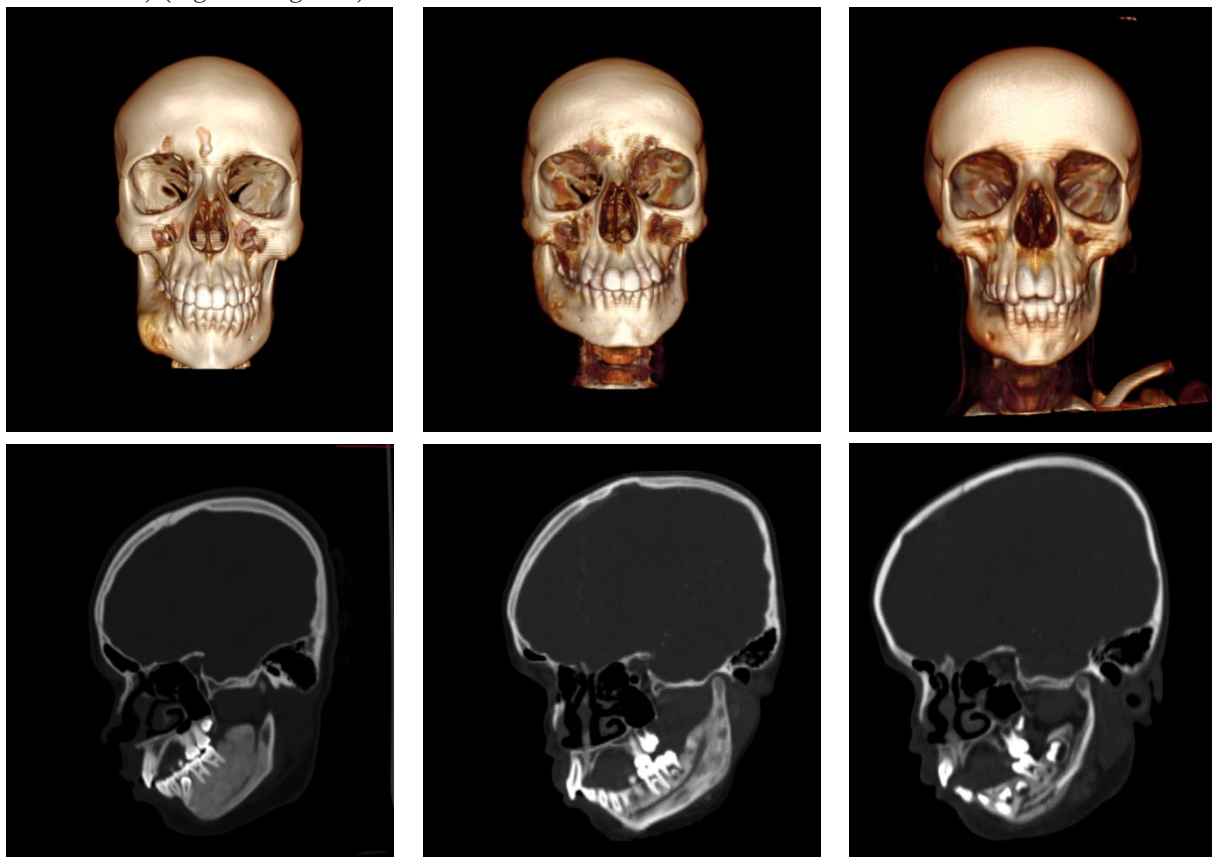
The relationship between the axial section of the course of the mandibular canal and the three-dimensional reconstruction of computed tomography data (3 patients) does not allow us to reliably judge the nature of the course depending on the exit location n. Mentalis
